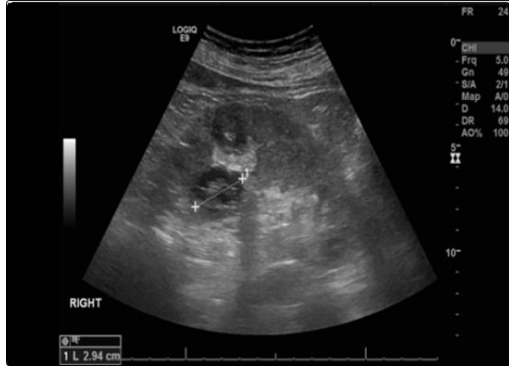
Ultrasound with contrast right kidney showing 2 complex cysts located in the anterior cortex. There is a 3.5 cm cystic lesion with focal echogenic area measuring 1.8 cm. There is a second complex cyst measuring 3.5 cm close to the posterior mid renal cortical lip. This second cyst has a slightly irregular border and central echogenic complex septi.
